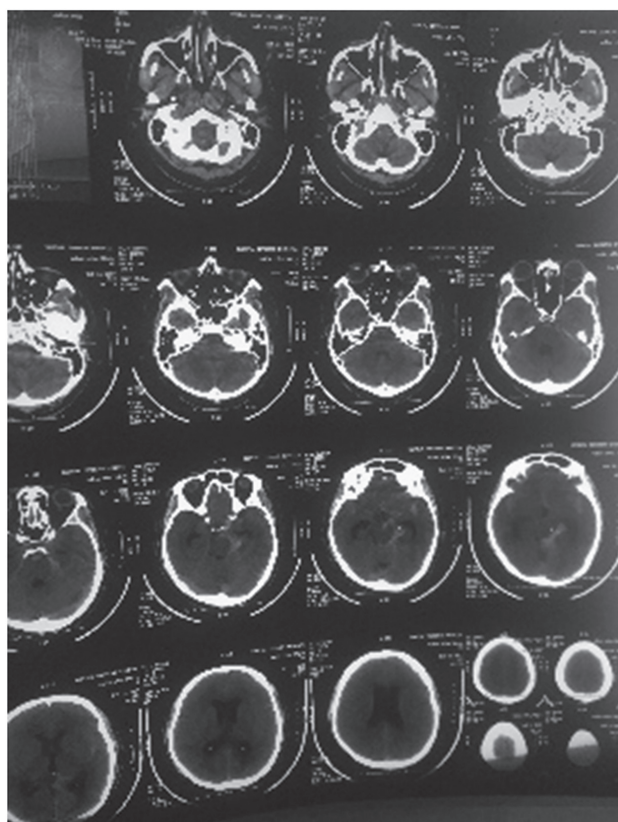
Preoperative plain CT scan of brain showing SAH and more blood on left basal cistern
